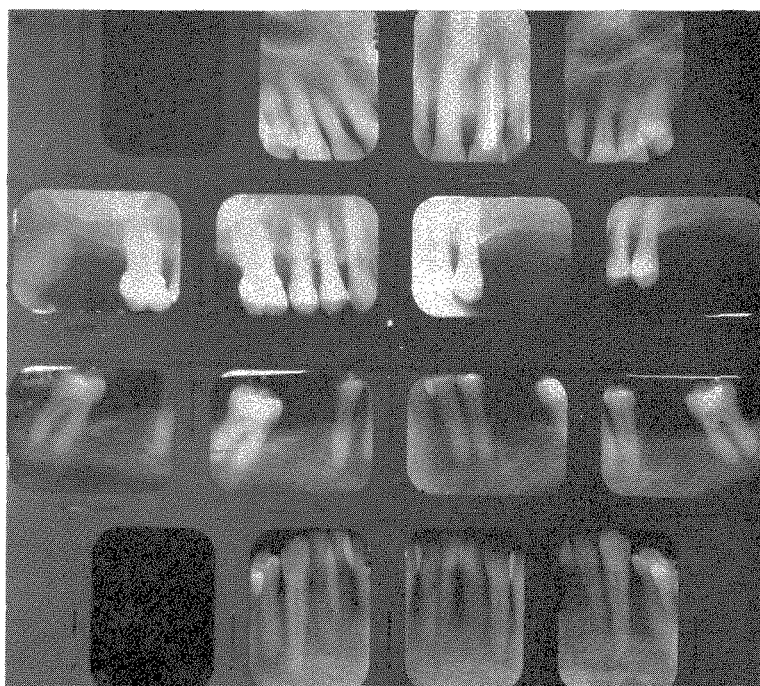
Roentgenograms of the patient taken in 1962 at the age of 64. In comparing these with those taken in 1946, little or no change could be detected.
